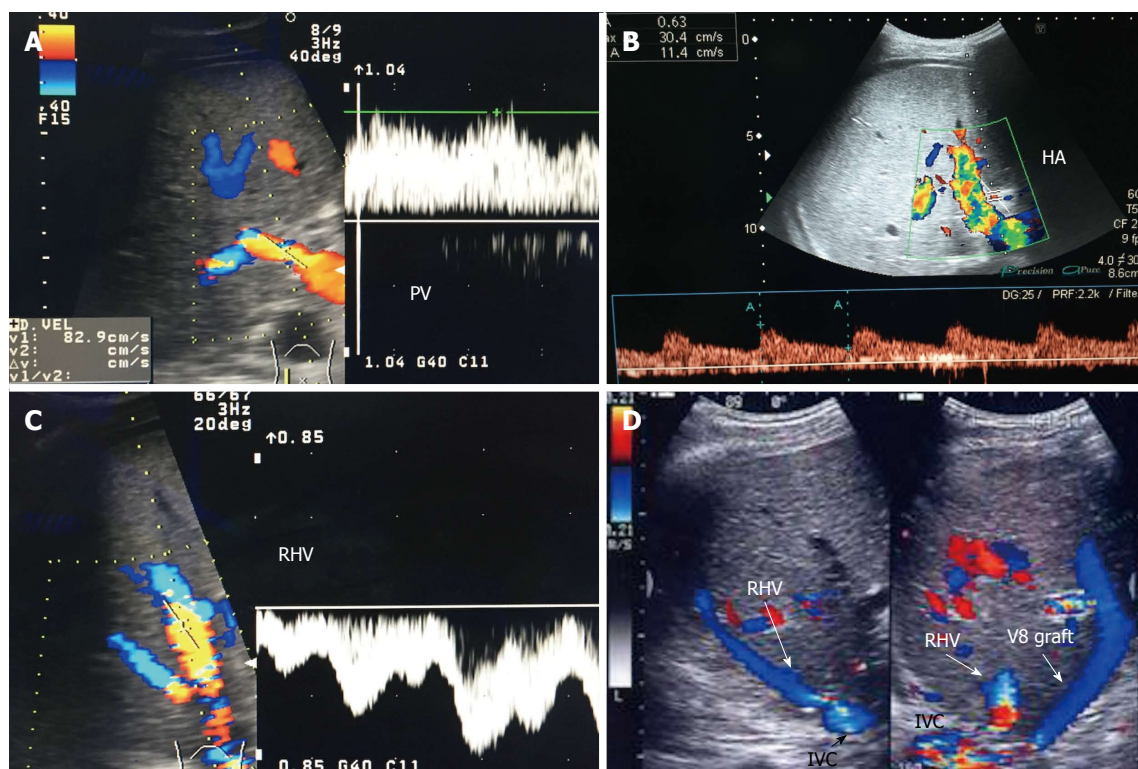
Post-operative Doppler ultrasound evaluation of the graft vasculature. A: Color Doppler image demonstrating normal petal, slightly turbulent, high flow in the PV (83 cm/s); B: Color Doppler image showing normal biphasic flow in the HA with normal RI = 0.63; C: Color Doppler image showing normal triphasic flow in the RHV; D: Color US image showing patent autologous V8 graft. PV: Portal vein; HA: Hepatic artery; IVC: Inferior vena cava; RHV: Right hepatic vein; V8: Segment VIII vein.
